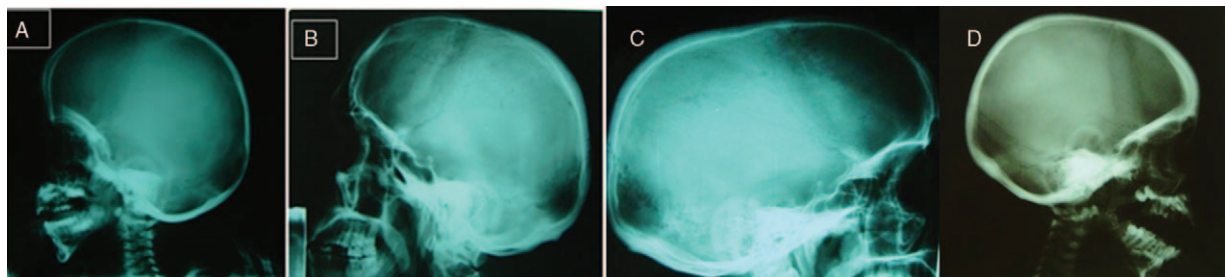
(A) lateral skull radiograph of a 5-year-old girl showed hyperostosis of the skull base and the calvarium. (B) Lateral skull radiograph of a 34-year-old father showed diffuse skull base sclerosis, J-shaped sella turcica overwhelmed by immense hyperostosis of the cranium. (C) Lateral skull radiograph of the spouse of Figure 3 showed calvarium thickening, similar but less sclerosis of the skull base and all patients showed wormian bones of the occipital areas with variable intensity. All patients showed J-shaped sella turcica. (D) Lateral skull radiograph of a 13-year-old girl showed sclerosis of the calvaria and hyperostosis of the skull base. All patients (children and adults) showed calvarial sclerosis, hyperostosis of the skull base, wormian bones, and J-shaped sella turcica.
